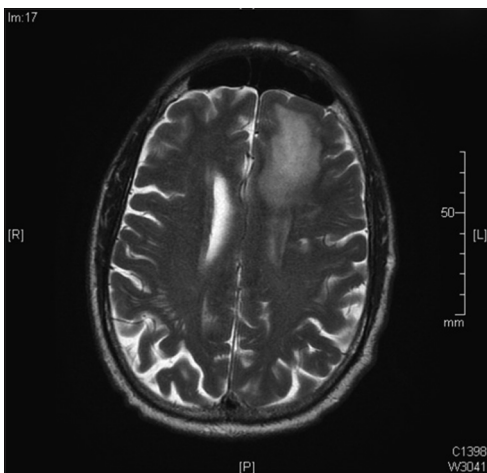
Magnetic resonance image of the brain showing an enhancing lesion in the left frontal lobe consistent with an abscess
